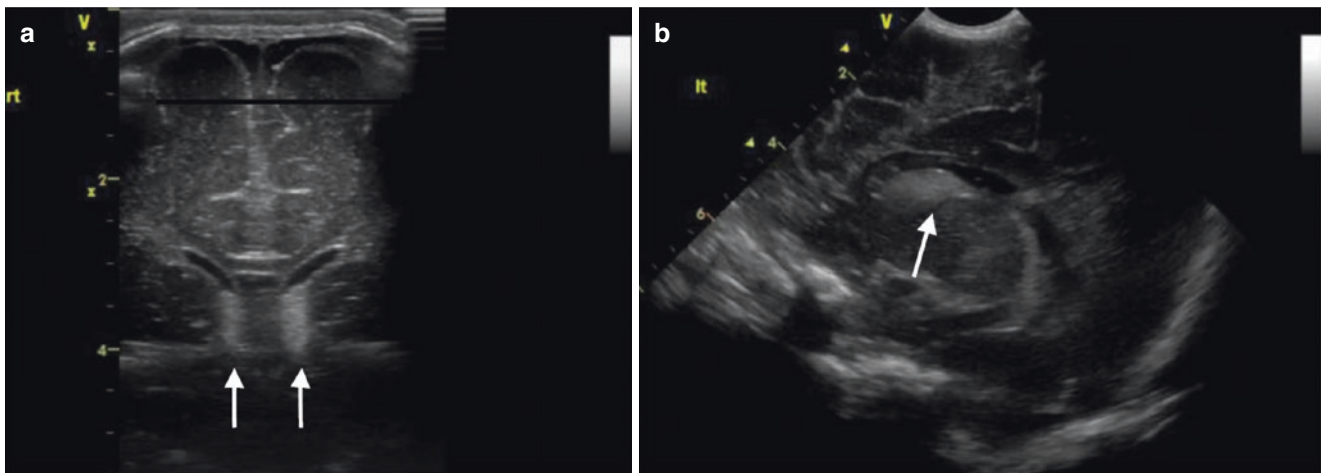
Bilateral grade 1 subependymal haemorrhages. (a) Coronal ultrasound image shows bilateral hyperechoic foci along the inferior frontal horns of the lateral ventricles. (b) Left parasagittal ultrasound image shows the hyperechoic haemorrhage within the caudothalamic groove
